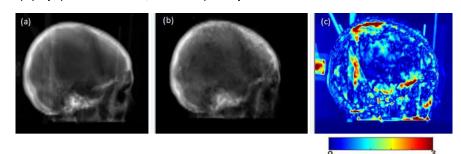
(b)Lateral DRRs from CT, (b) from sCT, (c) γ (DTA =2mm, Δ I=5%) map with reference CT-based DRR
